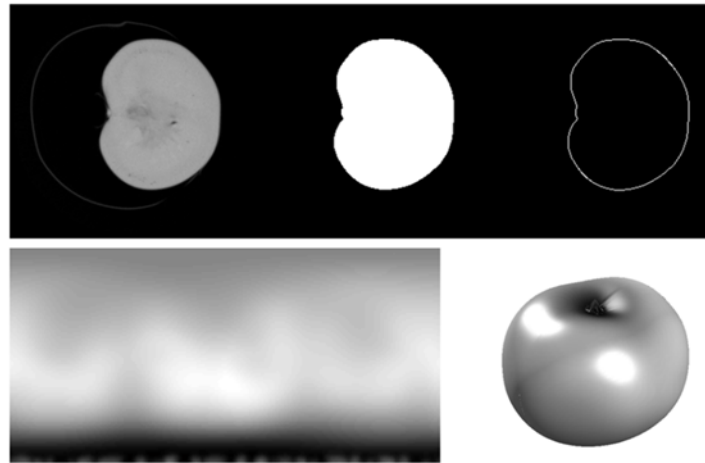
Top: Slice through a reconstructed CT scan (and image processing steps in a 2D representation). Bottom: Resulting surface representation (distance to center) in the spherical and Cartesian domain.
